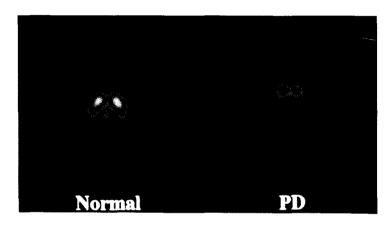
$[^{123}I]\beta$ -CIT SPECT images of a healthy subject and of a Parkinson's disease (PD) patient. In the patient with PD, $[^{123}I]\beta$ -CIT binding in the striatum is markedly reduced; a greater reduction occurred in the putamen than in the caudate.
